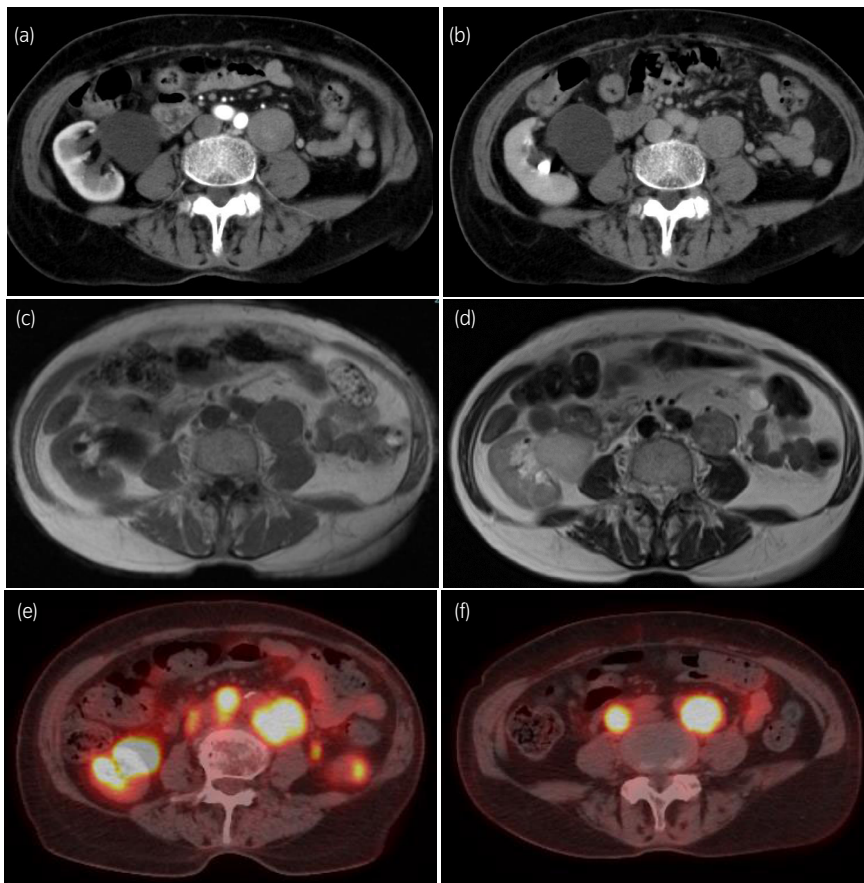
Imaging tests at the first diagnosis. (a, b) Abdominal computed tomography examination shows a tumor with 46-mm diameter on the left side of the abdominal aorta and right hydronephrosis due to pelvic ureteric junction stenosis. (a) early phase, (b) late phase. (c, d) Abdominal magnetic resonance imaging shows high signal in the tumor on the left side of the aorta. (c) T1-weighted image, (d) T2-weighted image. (e, f) FDG-position emission tomography shows strong FDG accumulation for the abdominal para-aortic region (e) and the bilateral common iliac artery regions (f).
